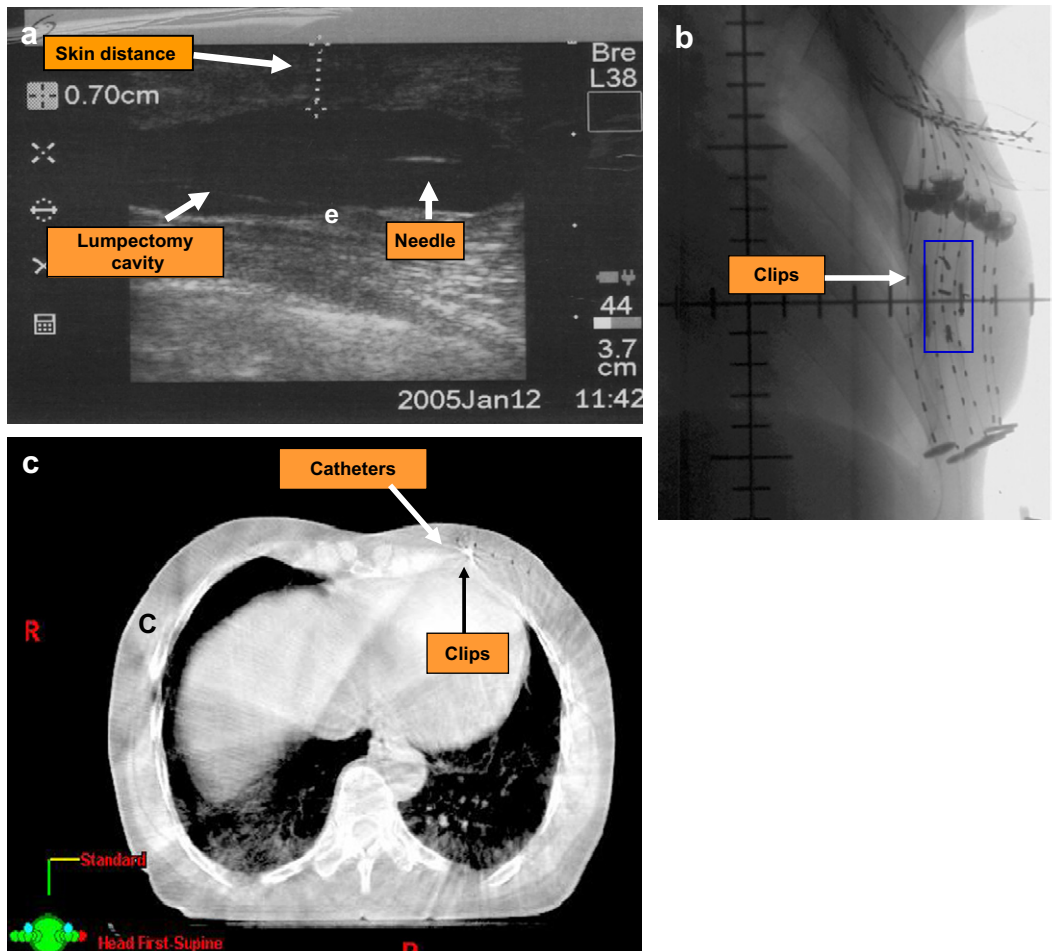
Evaluation of appropriateness of catheter placement by (a) intraoperative ultrasound; (b) orthogonal X-rays; and (c) computed axial tomography scan.
